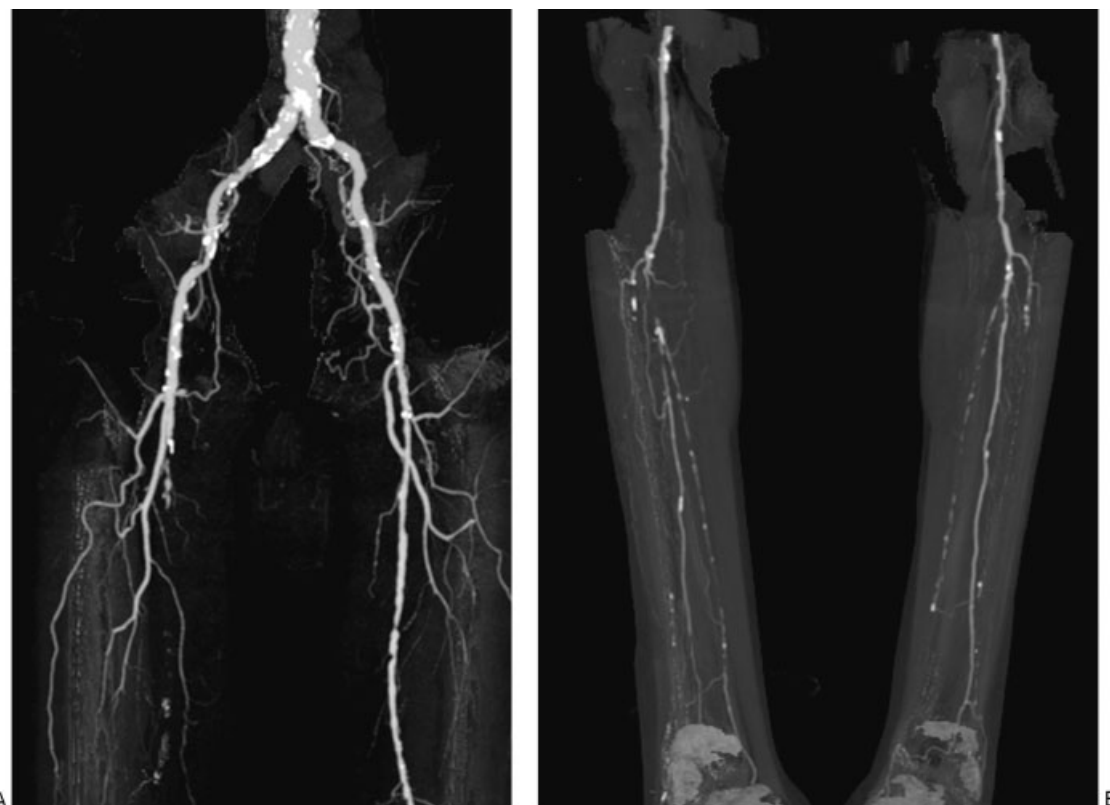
Computed tomographic angiography of 63-year-old man with right lower extremity rest pain due to outflow disease. (A) Maximal intensity projection image of the pelvis and thighs shows mild stenoses of the right common iliac and external iliac arteries with occlusion of the right superficial femoral artery. Multiple high-grade stenoses of the left superficial femoral artery are also noted. (B) Maximal intensity projection image of the calves show occlusion of the right posterior tibial (PT)-peroneal artery trunk with runoff via a reconstituted diseased peroneal artery. The PT artery is reconstituted at the ankle mortise by the communicating branch of the peroneal artery. Single-vessel runoff to the left foot is via a continuous but proximally diseased peroneal artery.
